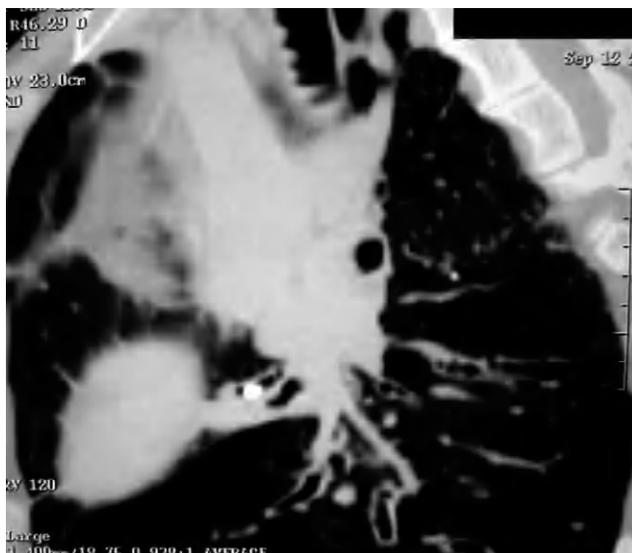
Computed tomography scan of the chest showing 2 calculi of 3 mm and 5 mm.
